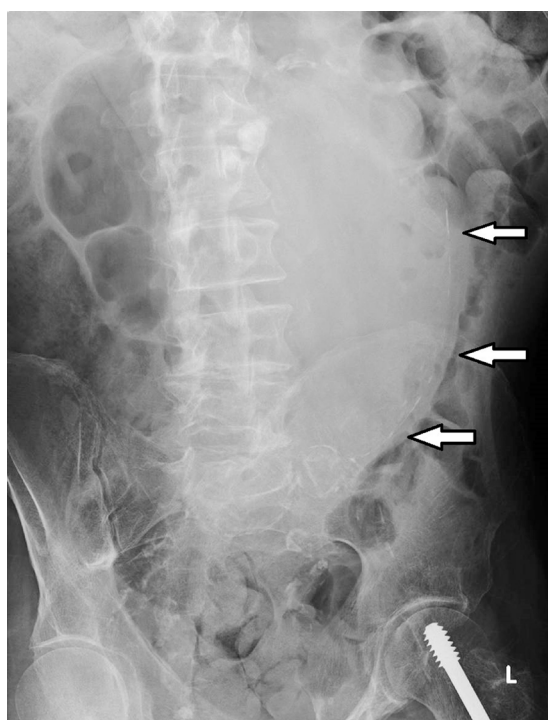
Abdominal X-Ray (White arrows show the aortic aneurysm and the calcification of the aortic wall)
